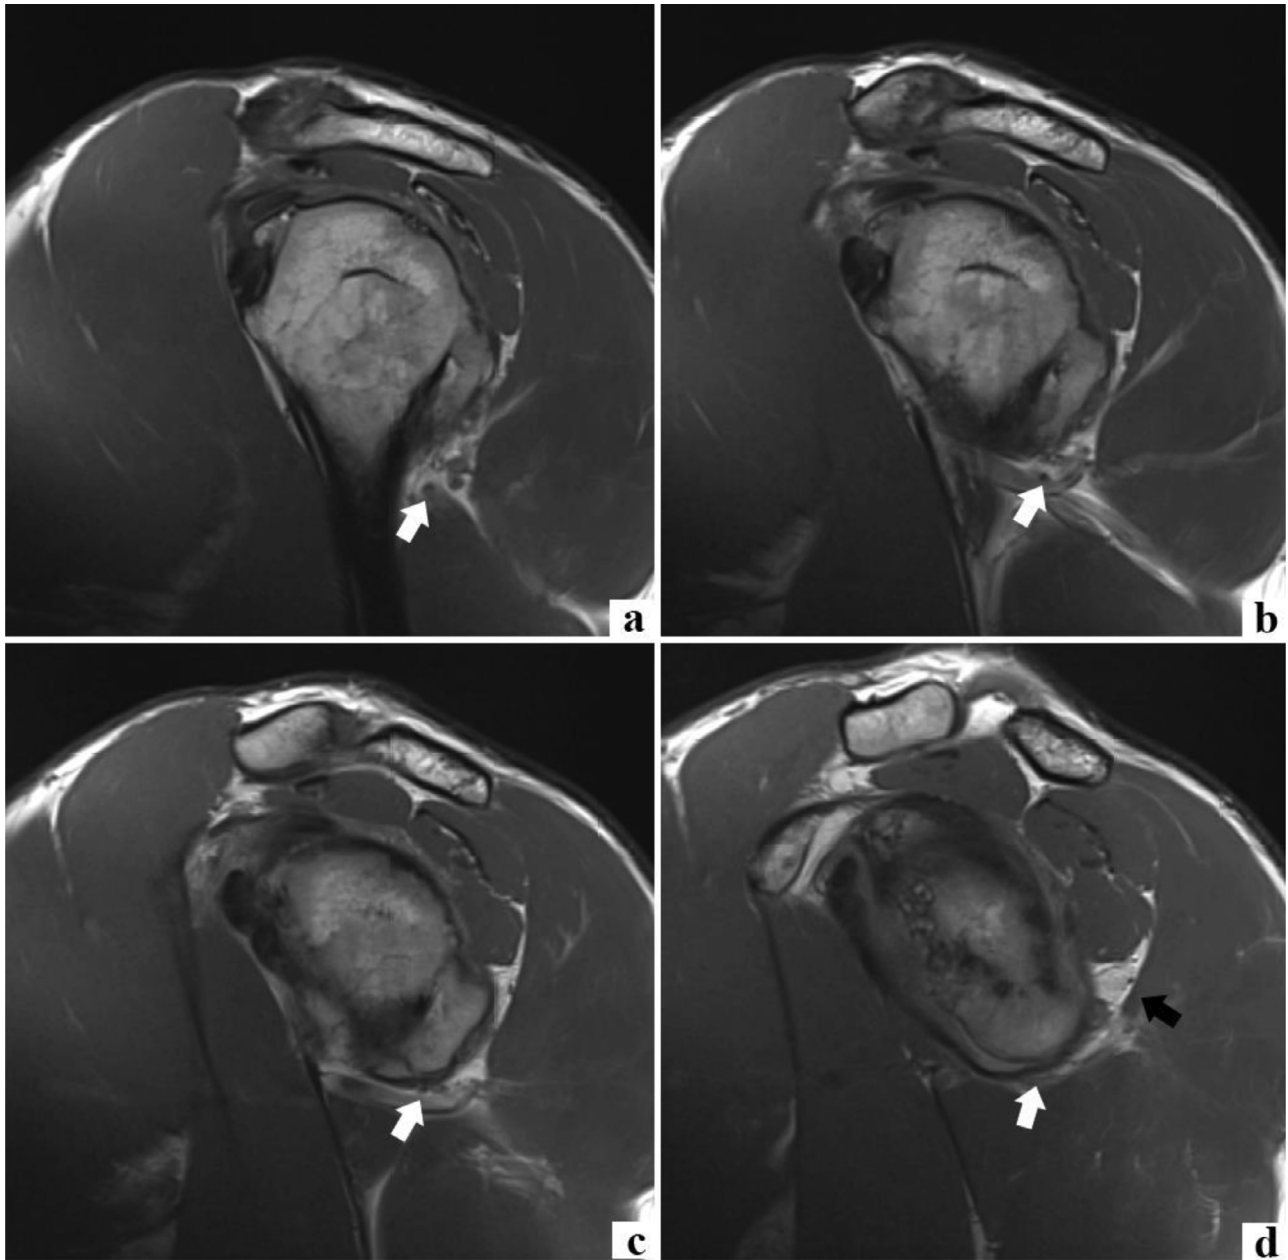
A series of T1 MRI sagittal images through the left shoulder going from most lateral at the level of the humeral head (A) to more medial at the level of the glenoid (D) demonstrates the quadrilateral space and axillary nerve (white arrow). The large osteophyte exerts mass effect upon the axillary nerve and narrows the quadrilateral space. Redemonstrated is fatty atrophy of the teres minor muscle (D, black arrow).
